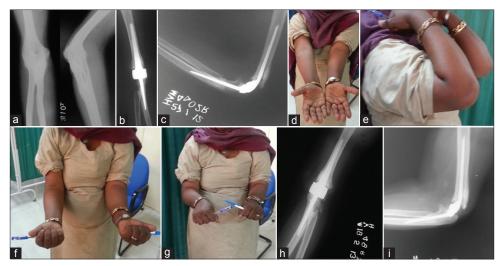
Preoperative X-ray of right elbow joint (anteroposterior and lateral views) in a posttraumatic arthritis showing (a) bony ankylosis of elbow joint (b-c) Postoperative X-ray of right elbow (anteroposterior and lateral views) showing Baksi implant *in situ* (d-g) Clinical photographs showing extension, flexion, supination and pronation (h-i) Final followup X-rays of right elbow showing Baksi implant *in situ*
